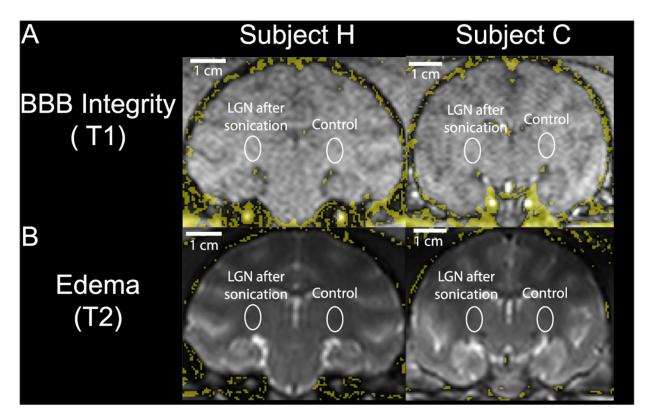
The stimulation does not disrupt the blood-brain barrier or cause edema. a) Ultrasound (1.5 MPa,  $I_{SPTA}$  of 7 W/cm<sup>2</sup>, 1 minute sonication, 30 ms pulse duration, 10% duty cycle) was delivered into the left LGN. Immediately following the sonication, we injected the contrast agent gadoteridol (ProHance, Bracco, 279.3 mg/ml). The top and bottom images show T1-weighted and T2-weighted MRI images, which quantify the difference before and after the administration of ultrasound and gadoteridol. The yellow regions show contrast greater than 10% on the T1 images and regions where the post image was greater than the pre image on the T2 images. The contrast was below this threshold within both LGNs (white circles), which is commonly taken as evidence of intact blood-brain barrier [35–38]. The lack of increased T2 signal in the brain (bottom) provides further evidence of safety as edema due to the ultrasound would result in an increased intensity on a T2 image [37].
